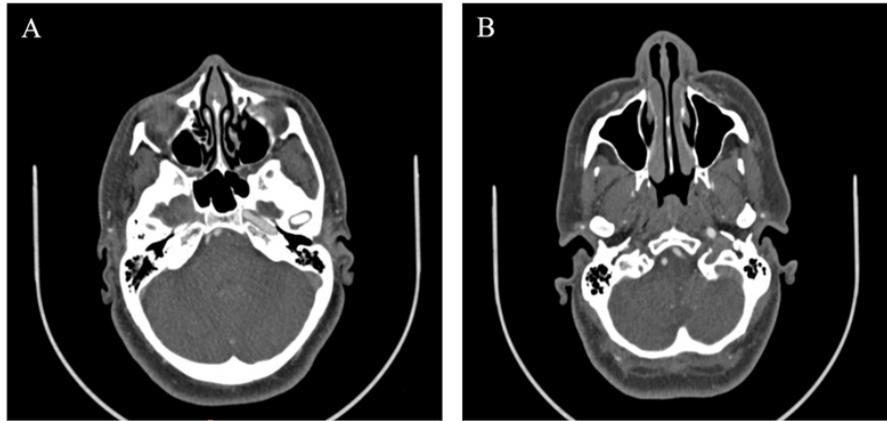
Axial CT scan of the base of the skull showing the absence of the right carotid canal (A). No opacification of the right internal carotid artery (B).
